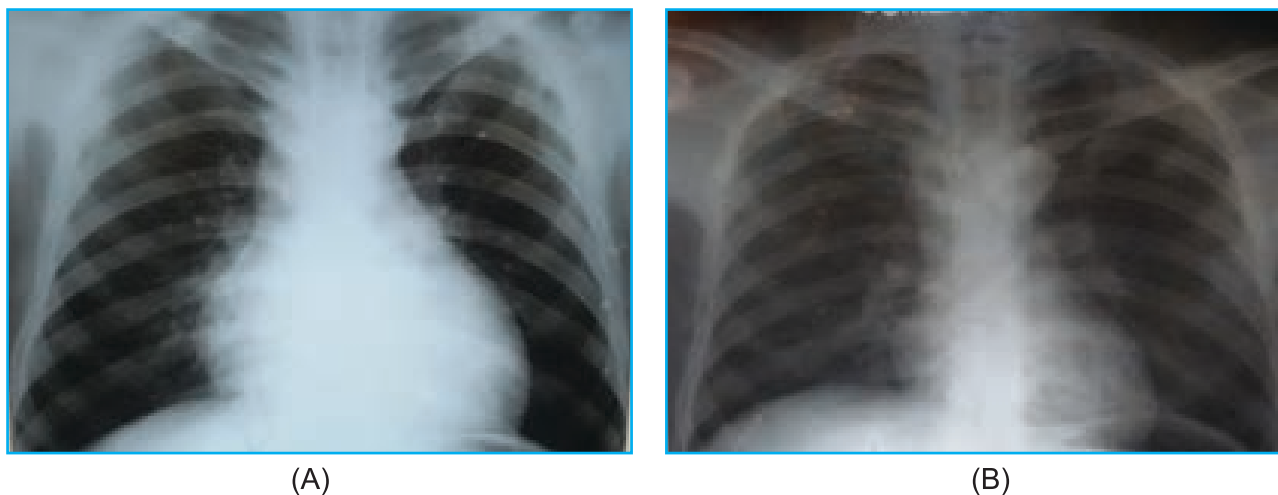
Chest x-ray PA view of the patient at presentation and after 2 months of therapy:
